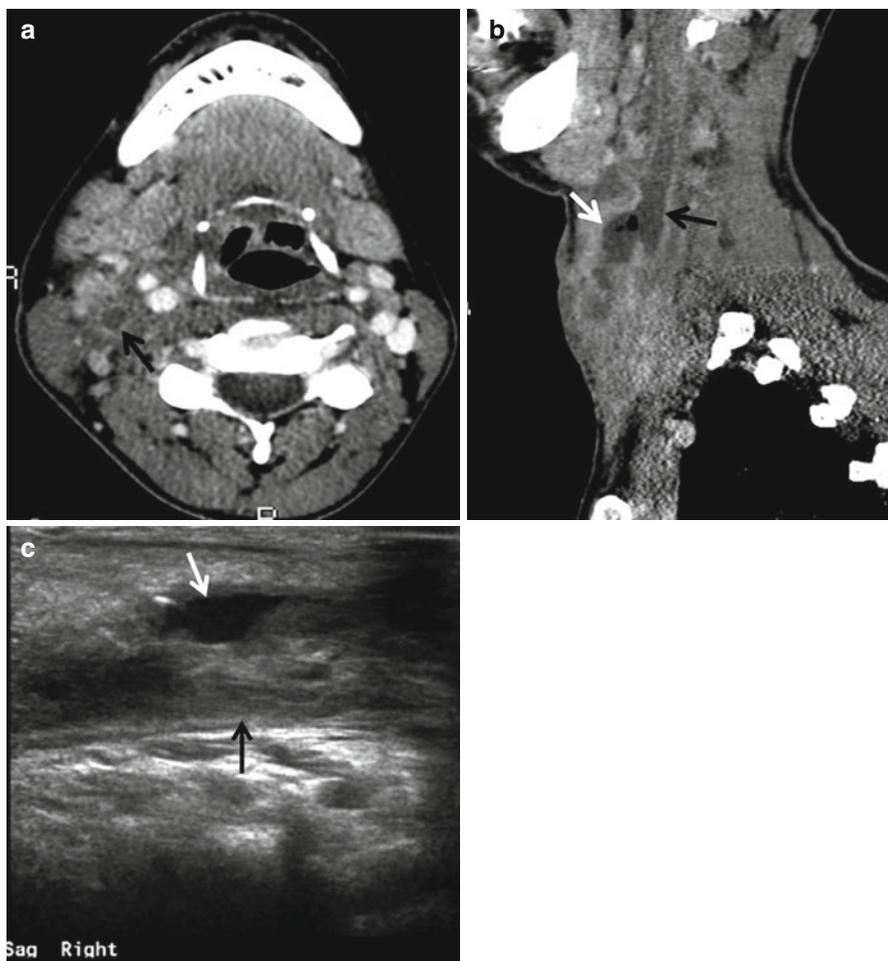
Internal jugular vein thrombosis with abscess. Axial and sagittal CT (a, b) and sagittal USG (c) demonstrate thrombosed right internal jugular vein (*black arrow*) in this young patient with history of intravenous drug abuse. The patient injected the drug directly into her right internal jugular vein. Note the abscess anterior to the thrombosed vein (*white arrow* in b and c)
